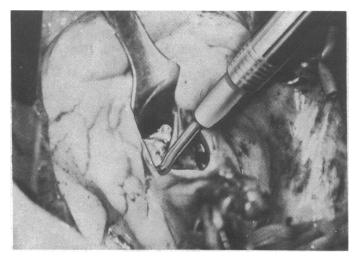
Case 1. Probe of ultrasonic instrument being used to undermine a calcific plaque.
